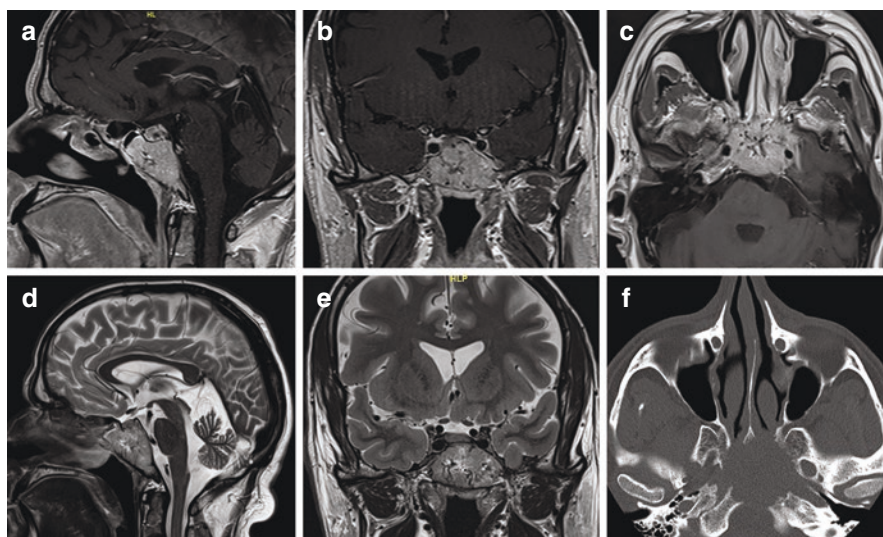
Clival metastasis from a renal clear cell carcinoma. Preoperative T1-weighted MRI with contrast (a–c) and T2-weighted images (d, e) reveal a large clival tumor with notable vascular voids. Significant bone erosion is seen on CT (f)
